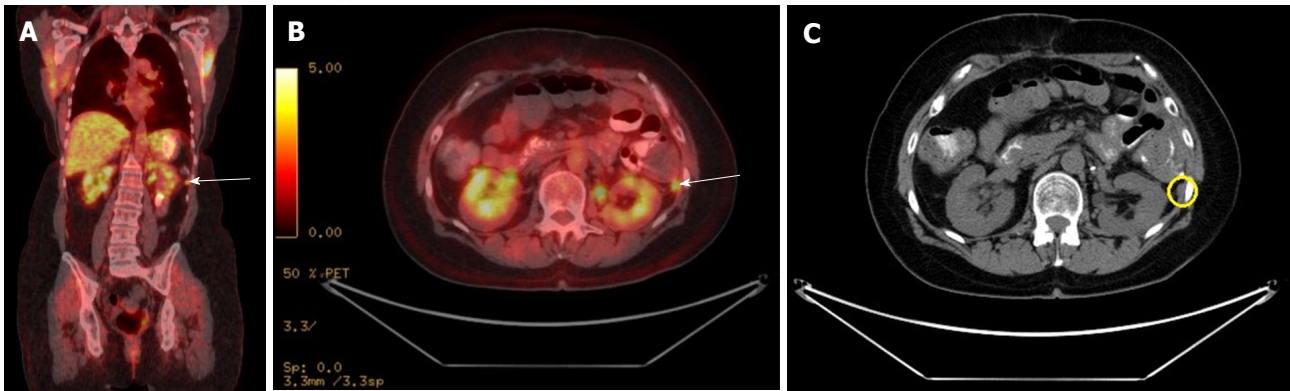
F-18 fluorodeoxy glucose avid solid pseudopapillary neoplasm metastases and metastatic solid pseudopapillary neoplasm to mesentery. A: FDG avid SPN metastases to mesentery; B: FDG avid metastatic SPN to mesentery; C: CT appearance of the FDG avid lesion. SPN: Solid pseudopapillary neoplasm; CT: Computed tomography; FDG: F-18 fluorodeoxy glucose.
